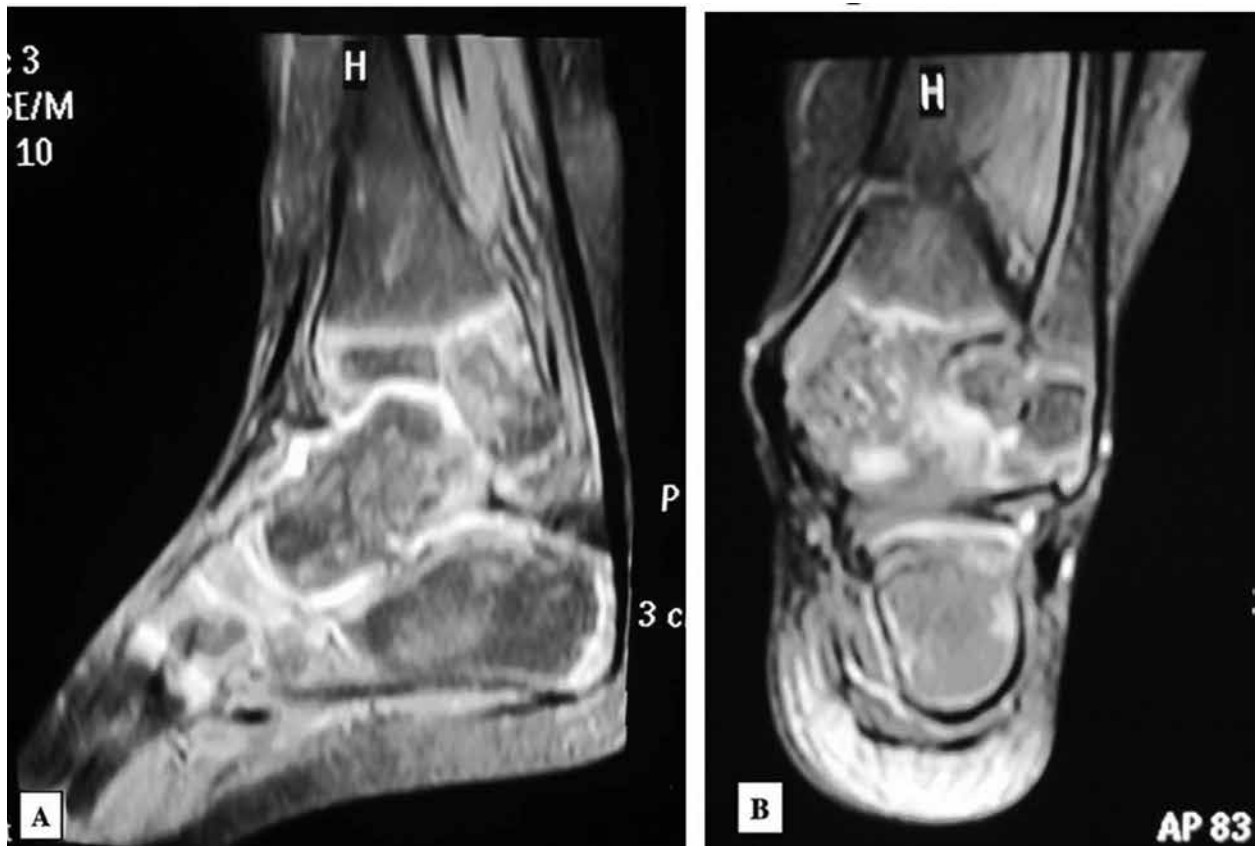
MRI findings in our patient, showing (A - B) a bony tumor measuring 2 x 3 cm on the medial side of the distal epiphysis of the tibia and talus. T2- weighted MRI showed intermediate to high signal intensity, with swelling of the surrounding soft tissues, increased effusion, and a heterogeneous signal in the left calcaneus and talus.
